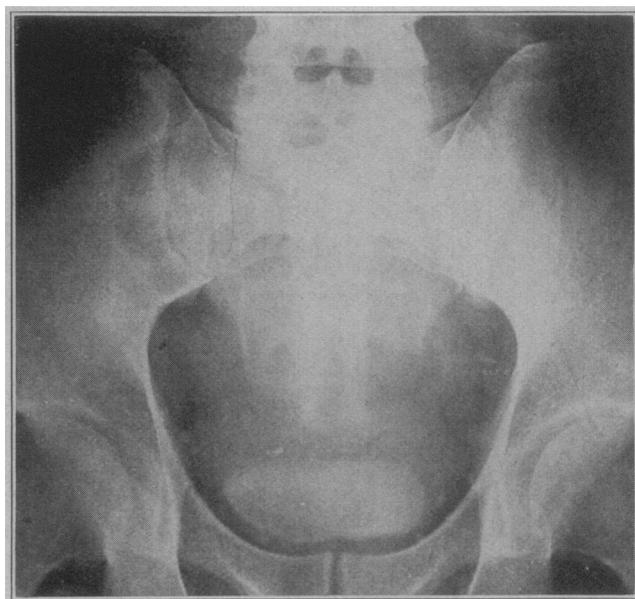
The patient received three 3 gm. doses of sodium iodid by mouth. Roentgenograms were made two hours after the last dose, and a shadow of the full bladder was obtained. The patient voided 125 c.c. of urine, and a roentgenogram was made which revealed retention that had not been suspected clinically. Further clinical study revealed the existence of a cord bladder.
